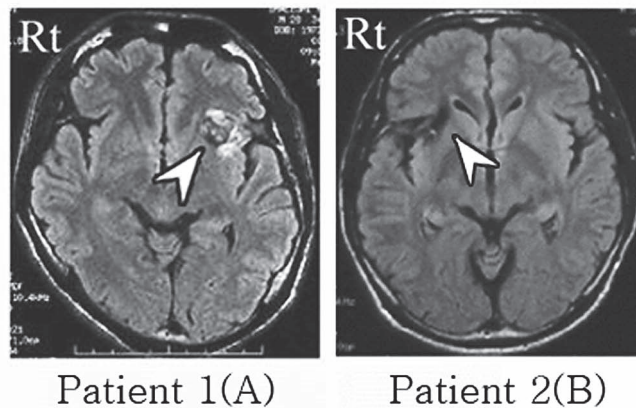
Fluid-attenuated inversion recovery magnetic resonance images of Patients 1 and 2. Cavernous angioma is located in the left (Patient 1, A) and right (Patient 2, B) anterior insulae (white arrowheads).
